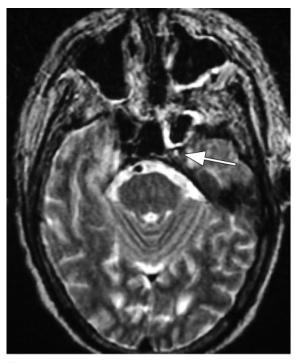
Acute invasive fungal sinusitis due to zygomycosis in a 59-year-old diabetic man with pain and swelling of the left eye and left-sided facial droop. (a) Axial T2-weighted MR image shows minimal mucosal thickening in the left sphenoid sinus. The normally expected flow void of the left carotid artery is absent (arrow). (b) Axial T2-weighted MR image obtained craniad to a shows an acute infarct involving the left temporal lobe (arrows). (c) Coronal unenhanced T1-weighted MR image shows soft-tissue thickening in the region of the left cavernous sinus (arrows) secondary to invasion of the cavernous sinus by the sphenoid sinus disease. Despite aggressive treatment with amphotericin B, the patient died 5 days later.
